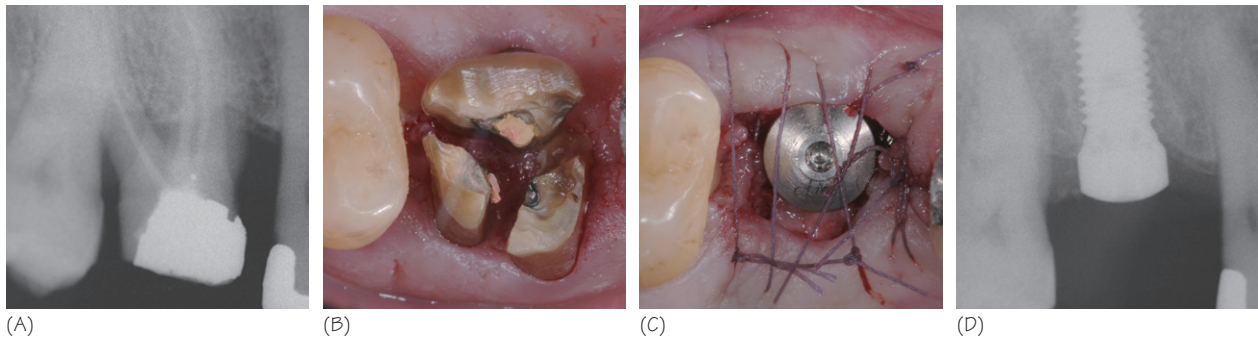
Immediate implant placement in molar site at the maxilla (one-stage procedure). (A) Preoperative X-ray of a hopeless first molar (pulp floor perforation). (B) Perioperative view of the extraction: root separation to preserve the inter-radicular septum. (C) Clinical view of the healing abutment after completion of the surgical procedure. (D) Postoperative X-ray 4 months after surgery.
